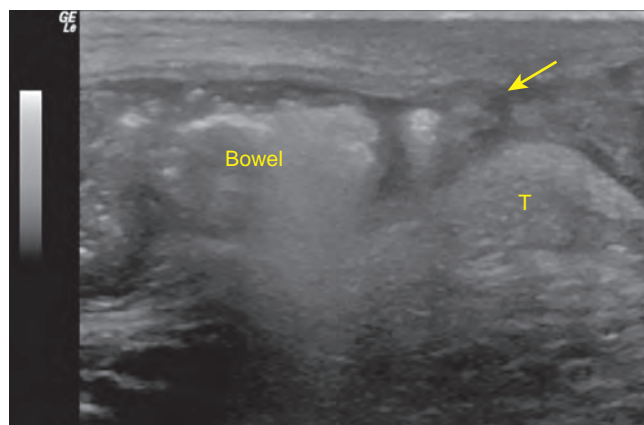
Sagittal image of a scrotal ultrasound in a 4-year-old boy with an inguinoscrotal bulge. Bowel is seen within the hernia sac that ends (arrow) superior to the testis (T) in the scrotum.
